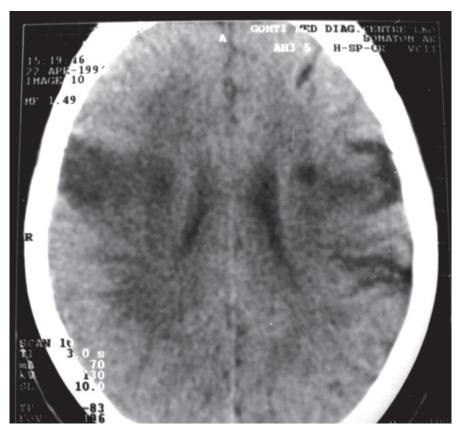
Brain CT scan of Patient 2 showing bilateral opercular infarcts
